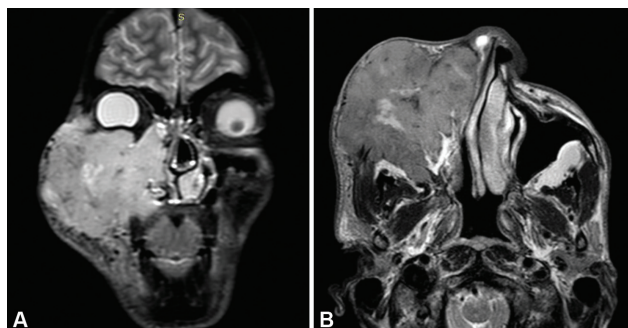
Nonkeratinizing squamous cell carcinoma of right maxillary sinus. (A) Coronal short tau inversion recovery image shows hyperintense irregular mass lesion of the right maxillary sinus invading the subcutaneous tissue and skin of cheek, hard palate, nasal cavity, right ethmoid sinus, and right orbit. (B) Axial T2-weighted image shows extension of mass into the right infratemporal fossa as well.
